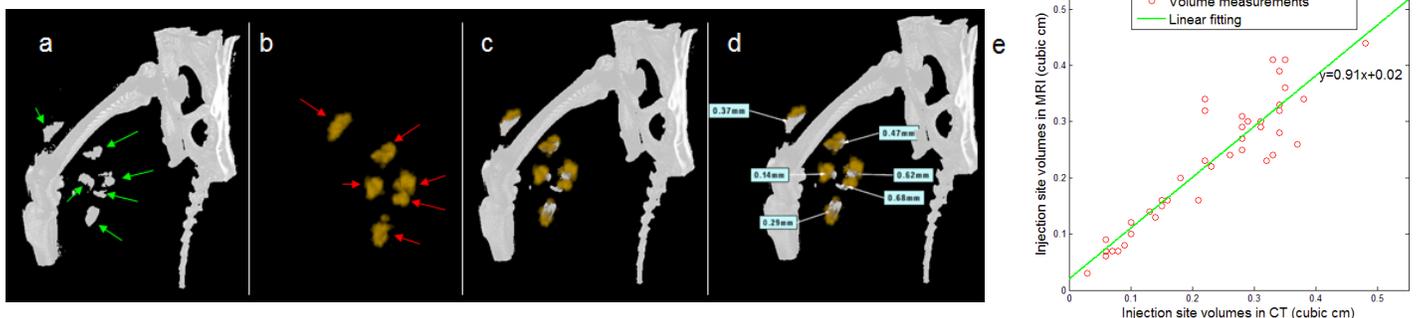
a) c-arm CT and b) ^{19}F MR images after thresholding reveal six injection sites of PFOB capsules (arrows). c) Co-registered images show a high concordance. d) Registration offset is small between COMs of each paired ^{19}F MRI and c-arm CT injection sites. e) Injection site volume measurements between CT and MRI show a high agreement.
